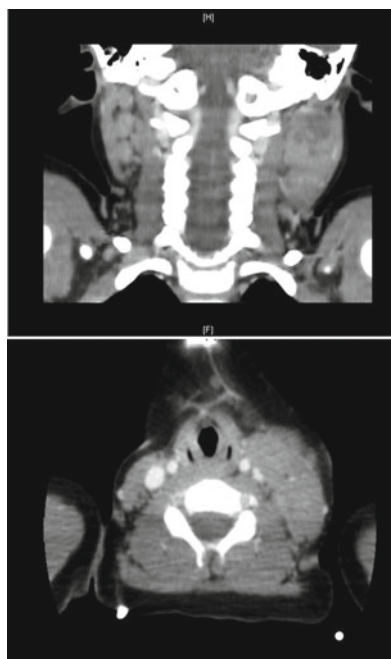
CT neck: Large inhomogeneous mass left side of the neck with lymphadenopathy displacing the left jugular vein. Irregular calcifications within the mass
